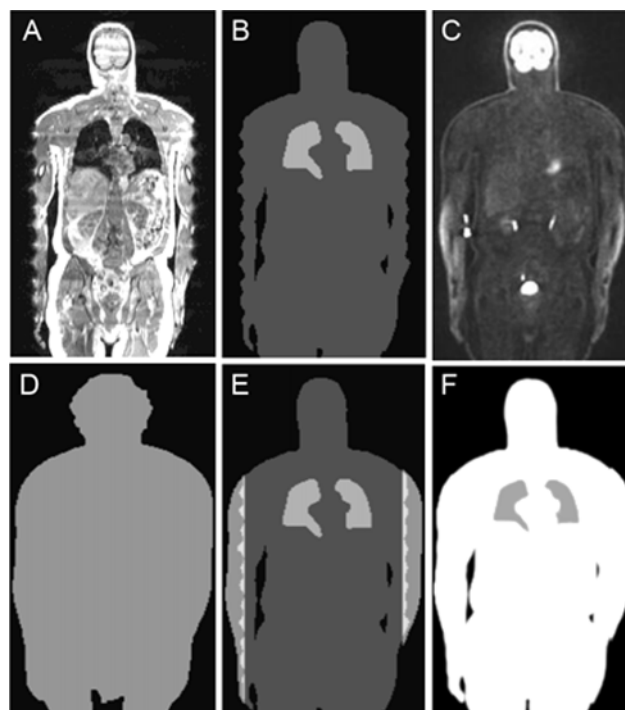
PET/MRI truncation compensation using PET segmentation. (A) truncated T1-weighted MR image, (B) three-class MRAC map, (C) NAC TOF PET image, (D) body contour derived from segmentation of NAC TOF PET image, (E) overlap of the attenuation map and the identified truncation regions, and (F) final truncation compensated attenuation map. Adapted with permission from Blaffert *et al.*, “Comparison of threshold-based and watershed-based segmentation for the truncation compensation of PET/MR images,” *Proc. SPIE* 8314, 831403-1–831403-12 (2012). Copyright 2012 by SPIE.
